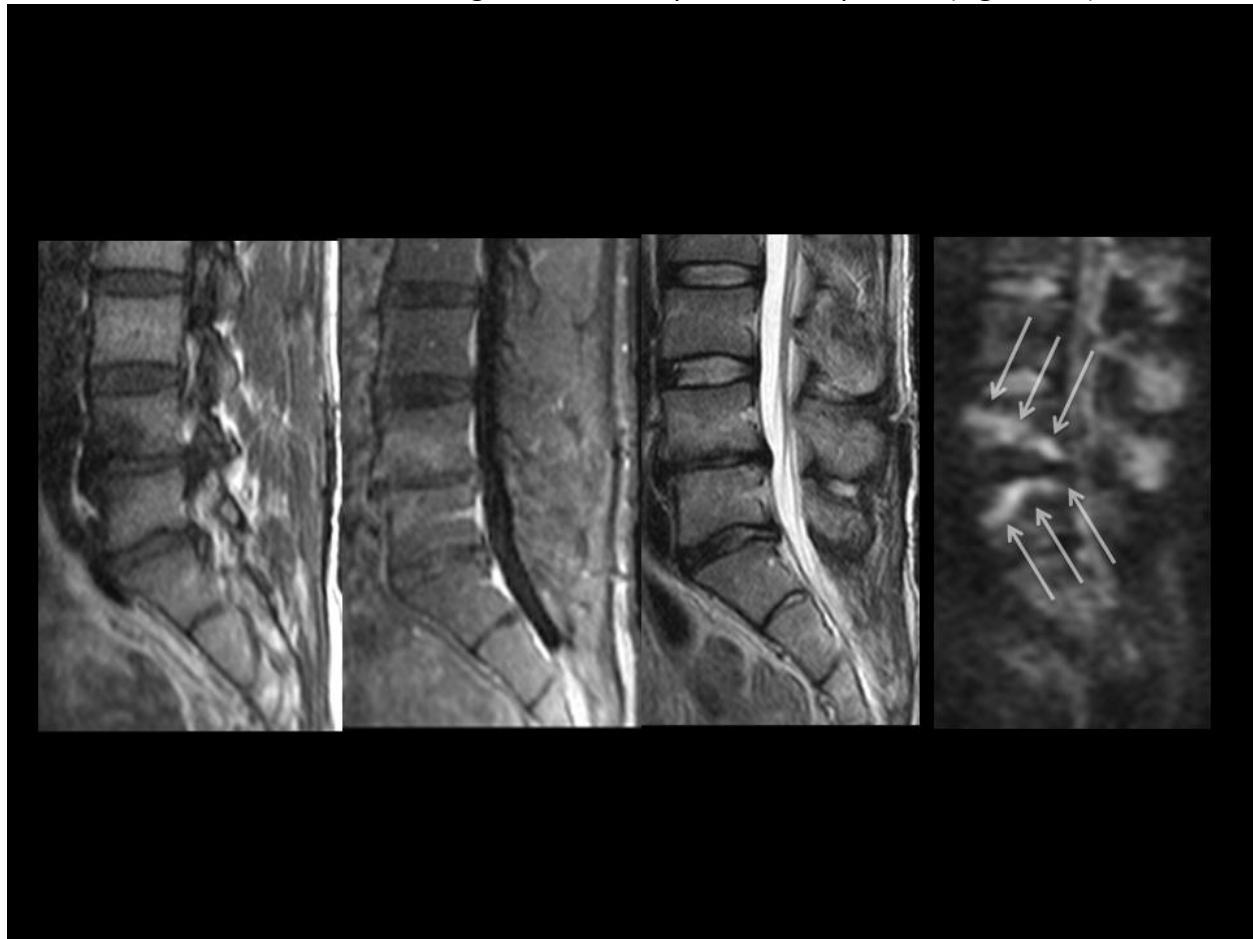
“Claw –sign” Modic I changes. From left: T1 FLAIR, contrast enhanced-fat suppressed T1 FLAIR, T2, DWI. Note the non-specific signal changes about the L4-5 disc space on routine imaging sequences. The DWI reveals paired well defined linear regions of increased signal at the border zone between the abnormal and normal marrow mitigating against the likelihood of infection.
